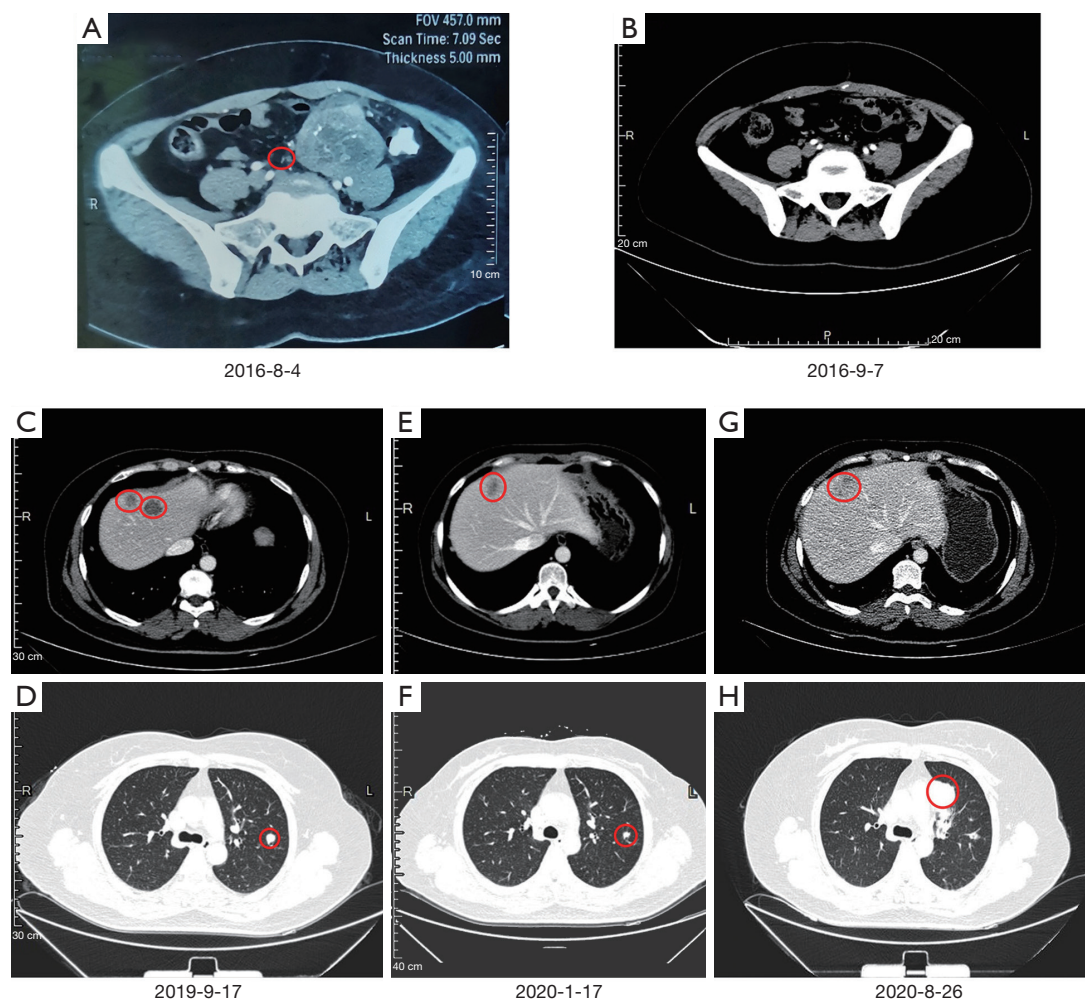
The CT images of the tumor lesions during treatment. (A) Baseline: a mass in the left pelvic cavity. (B) After surgery, no lesion could be observed. (C,D) Liver and lung metastases after anlotinib treatment. (E,F) Three months after olaparib therapy, reduced lesions were observed in the liver and lungs. (G,H) Increased metastatic lesions in both the lungs and liver in August 2020. Red circles represent the location and size of the lesions. R indicated the right side, and L indicated the left side in the CT images. CT, computed tomography.
